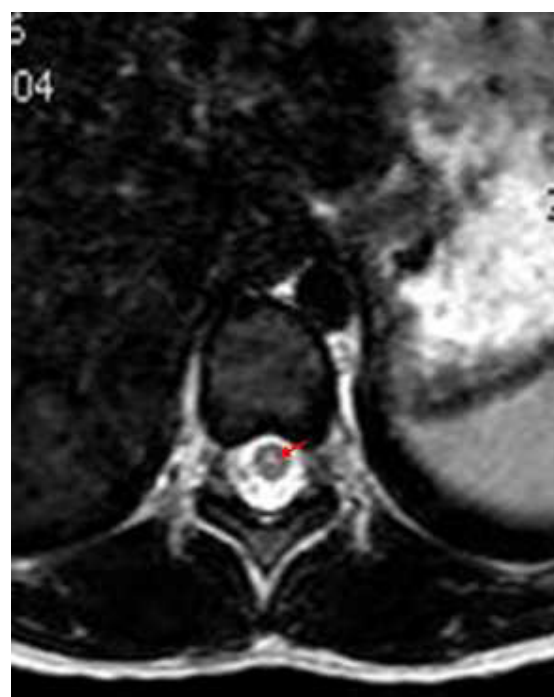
Subtle visualization of central canal (arrow) in axial MRI scan of spinal cord.
